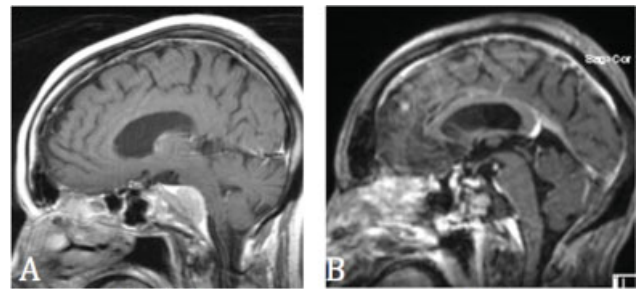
(A) MRI of preoperative meningioma; (B) Postoperative MRI with near total resection
